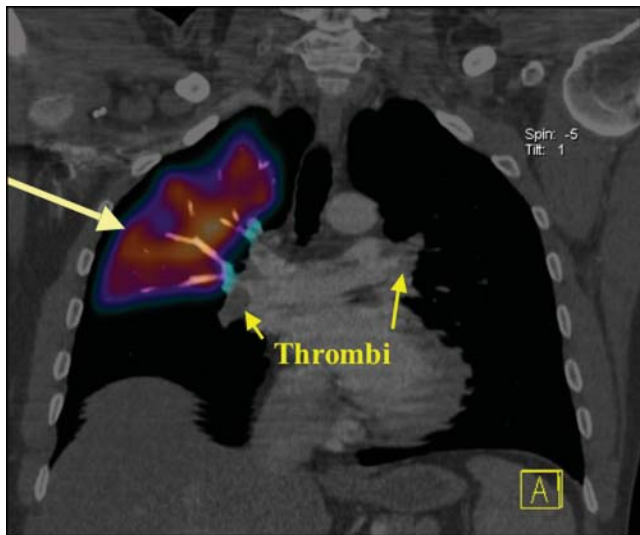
^{99m}Tc SPECT/CT angiography in a 45-year-old patient 2 days after hip surgery, who experienced sudden onset of severe shortness of breath, showed absence of blood flow to the entire left lung and right lower lobe.
